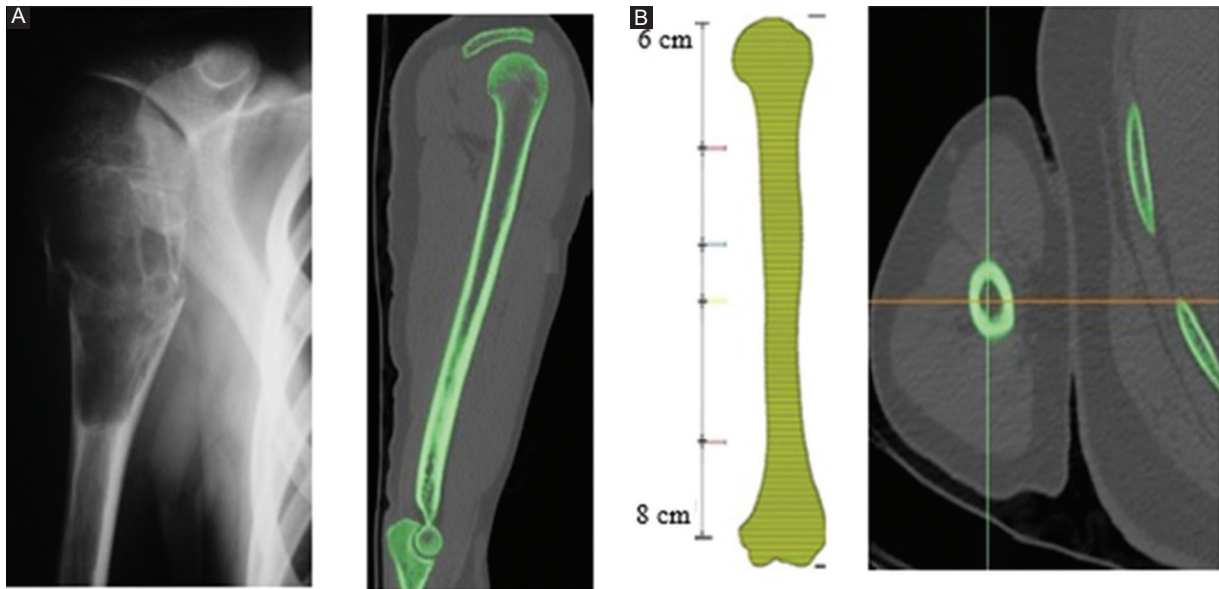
A: X-ray of humerus with tumor, with existing tumors dimensions being obtained at Instituto Nacional de Rehabilitación "Luis Guillermo Ibarra Ibarra". B: Tumor-free humerus CT scan of a patient who is candidate for a prosthesis.
